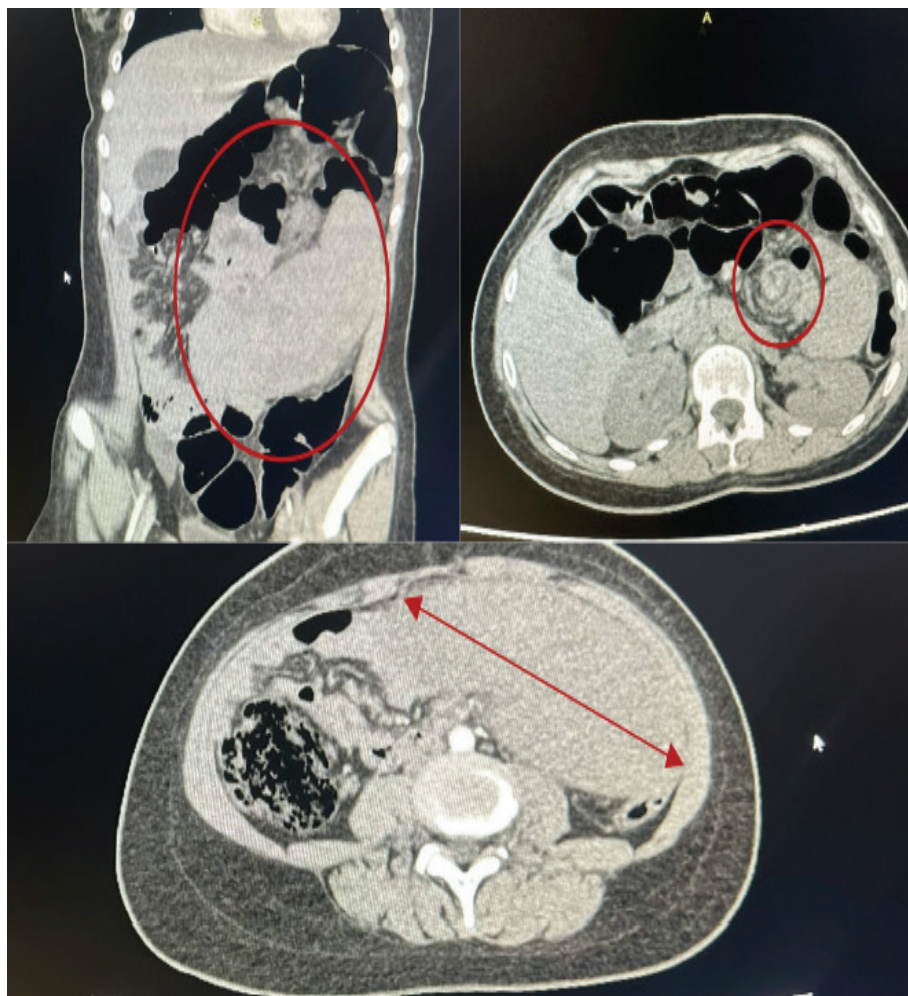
CT image of splenic torsion with hemorrhagic infarction and splenomegaly
